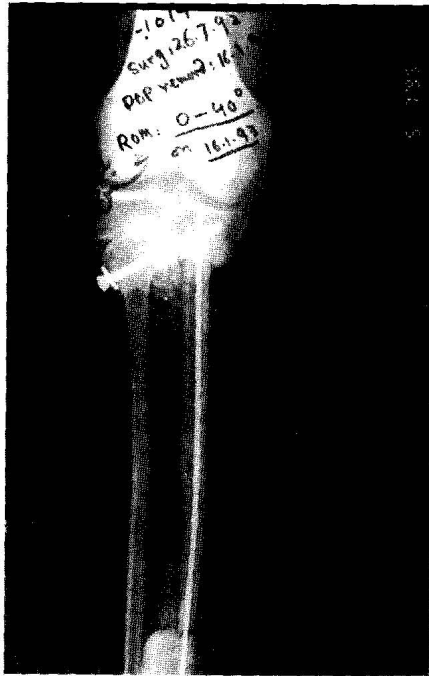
Postoperative x-rays of the patient showing centralization of the ipsilateral fibula and free fibular grafting of the contralateral fibula. Fixation done with kirschner wire and a cancellous screw.
